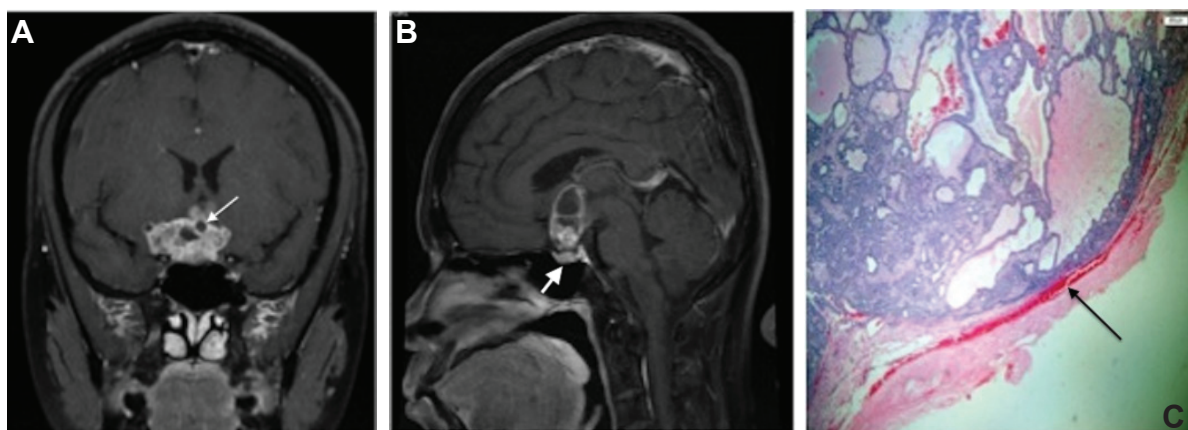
(A) Post contrast coronal T1-weighted image of a woman with craniopharyngioma shows a lobulated mix solid cystic lesion with rim enhancement of the cystic portion (arrow). (B) Sagittal T1 post contrast of a woman with craniopharyngioma shows a lobulated mix solid cystic lesion with rim enhancement of the cystic portion. Also noted tumor locates in suprasellar and can be separated from the normal pituitary gland (arrow). (C). Pathology (low power field) of patient A shows prominent vascular space in the cyst wall (arrow).
